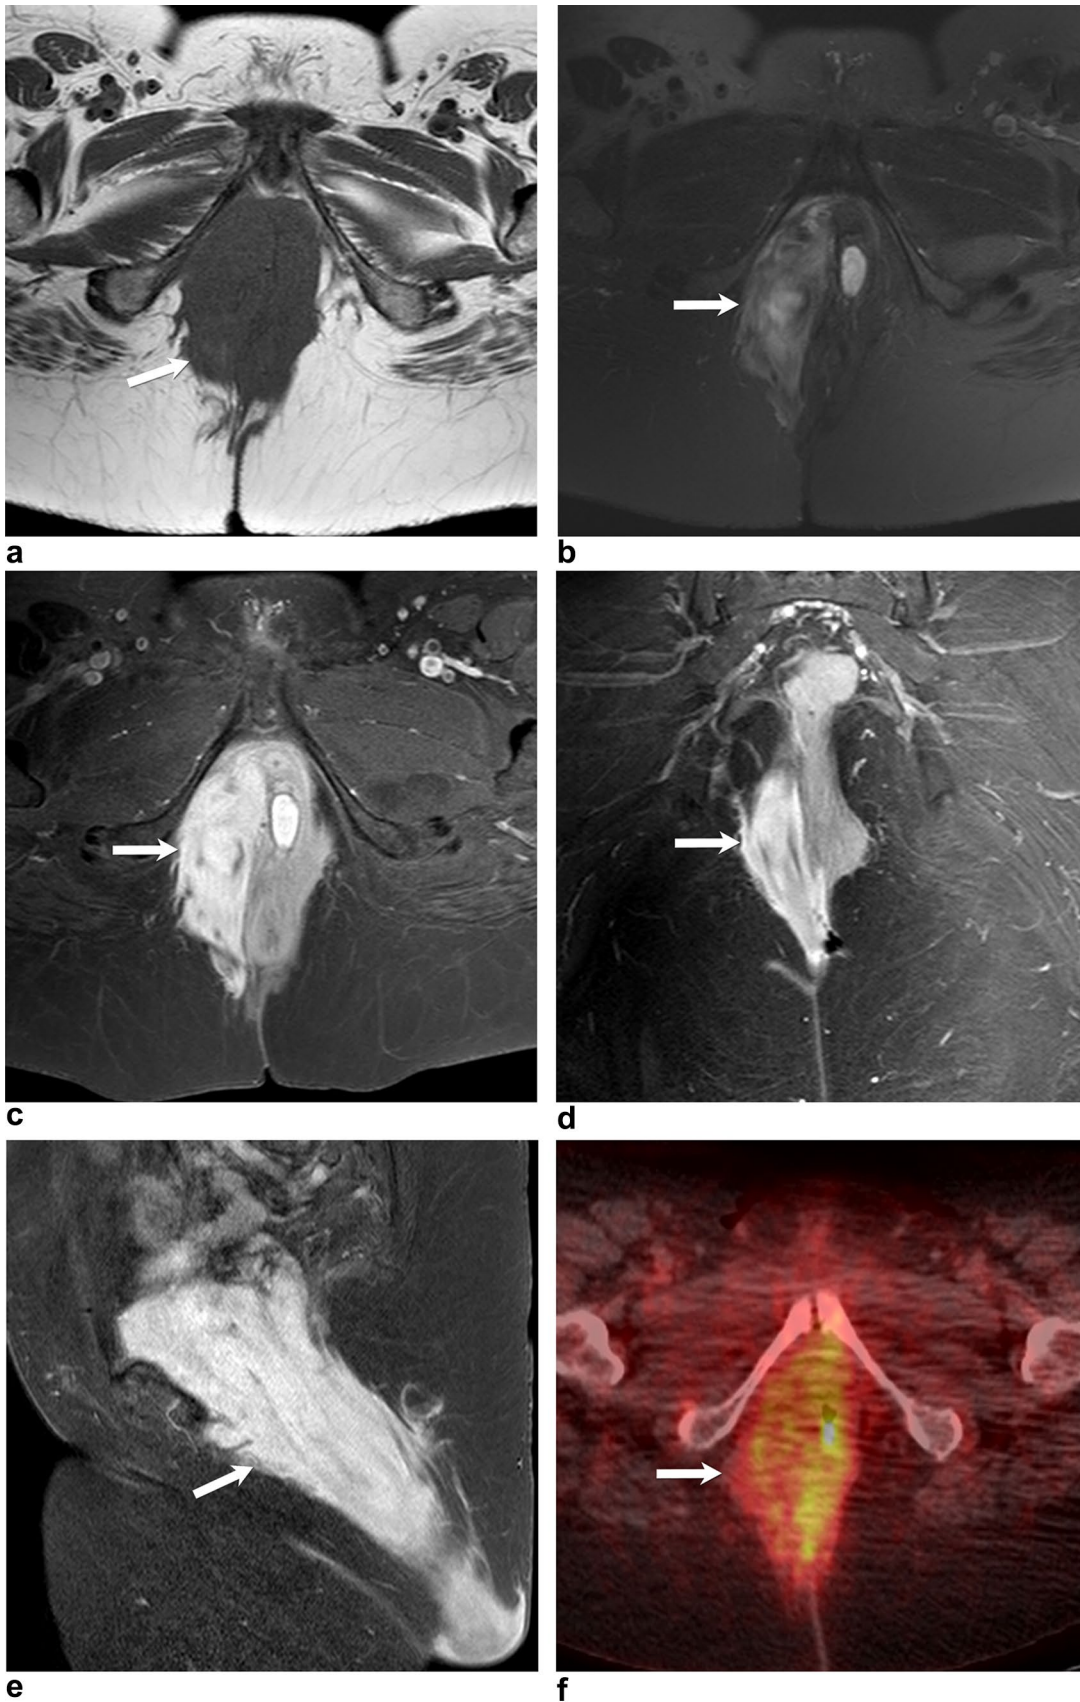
60-year-old female with a pelvic mass. a–c Pelvic MRI, Axial T1WI (a) and axial SPIR T2WI (b) showing a large mass (white arrow) in the right ischio-rectal fossa with low signal in T1WI and high signal in T2WI (white arrow) with intense enhancement in post-contrast T1WI (white arrow) (c). d, e Pelvic MRI, Coronal (d) and Sagittal (e) post-contrast T1WIs demonstrate the mass (white arrow) extending from the ischio-rectal fossa to the right gluteal region. Note the laminated appearance. f Axial PET/CT image shows the aforementioned mass (white arrow) with low level FDG uptake. Biopsy confirmed the diagnosis of aggressive angiofibroma
